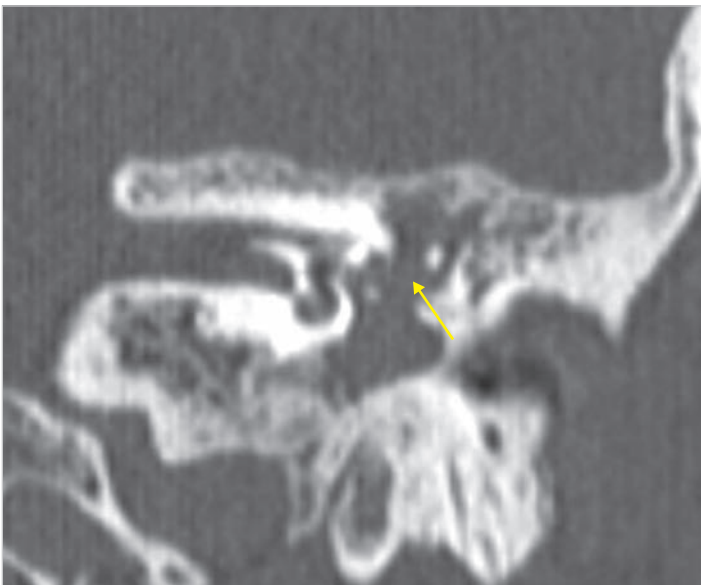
CT scan of the same patient, coronal view. The cholesteatoma erodes incudostapedial joint (*arrow*), resulting in progressive hearing loss.
